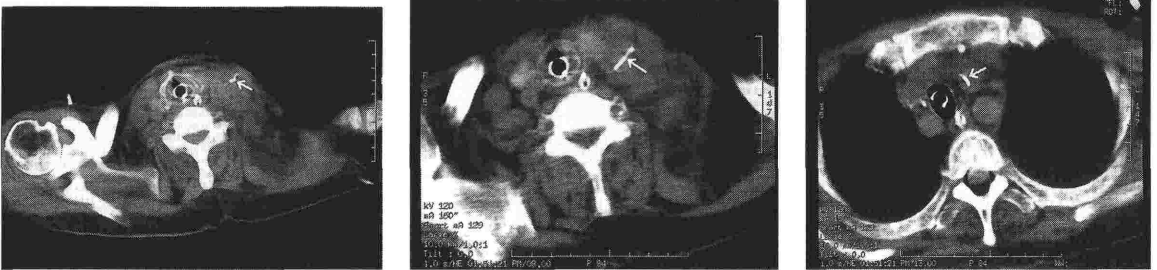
Cervical CT Scan Images
